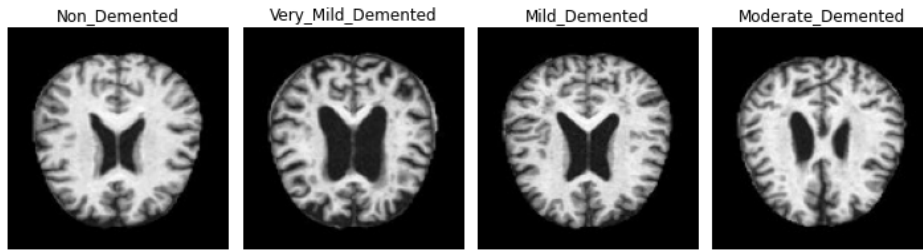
Samples from MRI dataset
